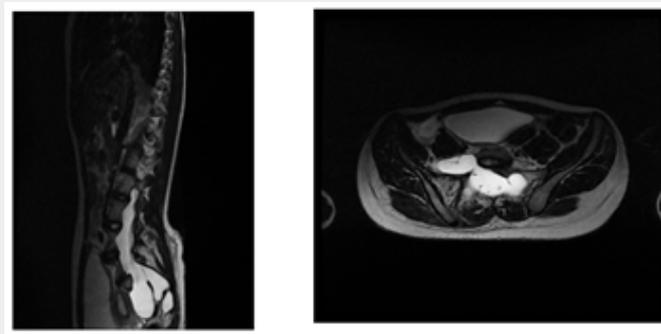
Medullary MRI in sagittal cut T1 (a), sagittal T2 (b), axial T2 (c) showing a dural ectasia lombosacred.
